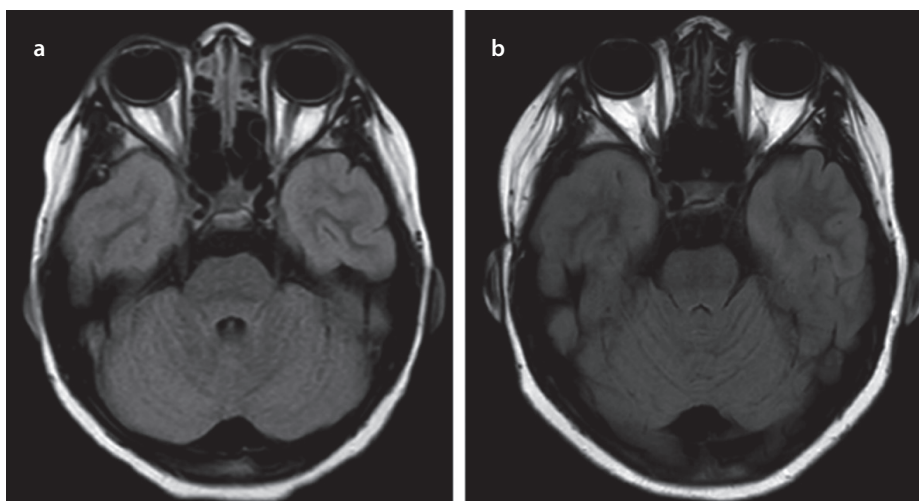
a, b. MRI of head. Axial T2 FLAIR SENSE scan from initial presentation demonstrating dural thickening of the right cavernous sinus (a); Axial FLAIR from two years after initial presentation and following treatment with adalimumab. The scan is unremarkable and demonstrates the remission of active disease (b).
